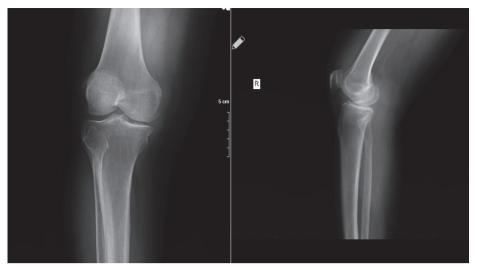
Radiography of the right knee: Increase of subchondral sclerosis and calcification of meniscus.
